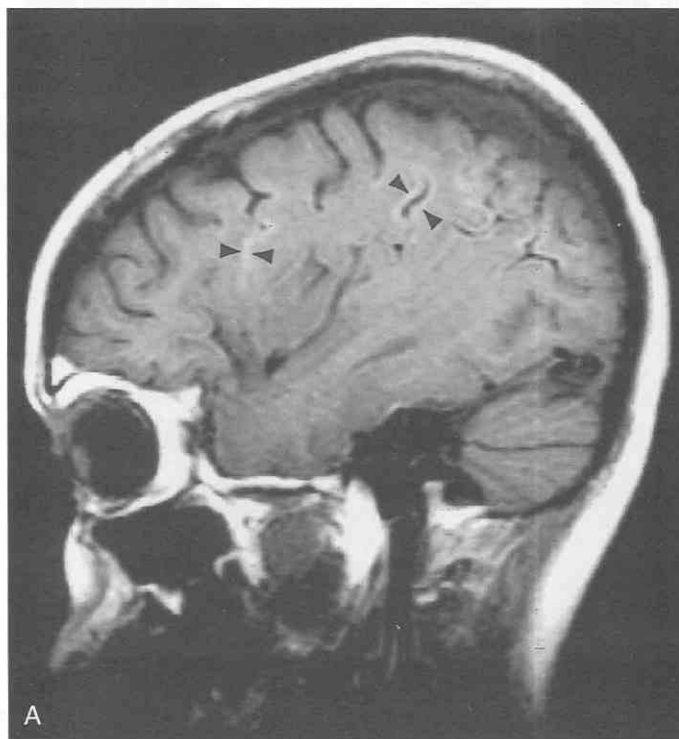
Cortical laminar necrosis. A and B, T1-weighted sagittal and axial images show cortical gyral increased signal (*arrowheads*) without substantial volume loss. The extent matches the expected left cortical middle cerebral artery territory. The signal changes are thought to represent mineralization within tissue damaged by ischemia.
